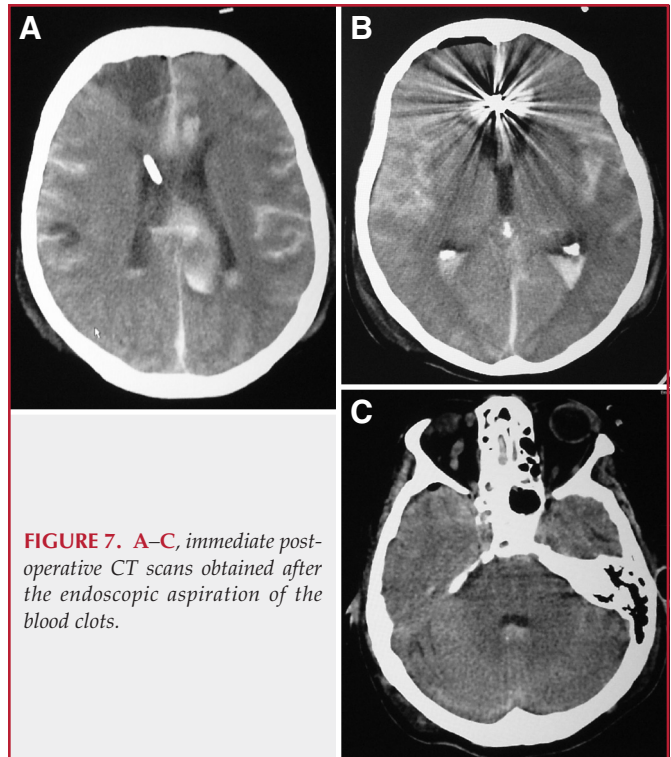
A–C, immediate post-operative CT scans obtained after the endoscopic aspiration of the blood clots.
